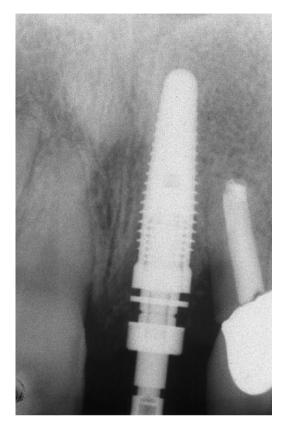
A radiograph taken following implant placement demonstrates the extensive repositioning of the alveolar bone which has taken place on the mesial aspect of the lateral incisor. This bone will be crucial to the support and maintenance of the interproximal soft-tissue papilla.
